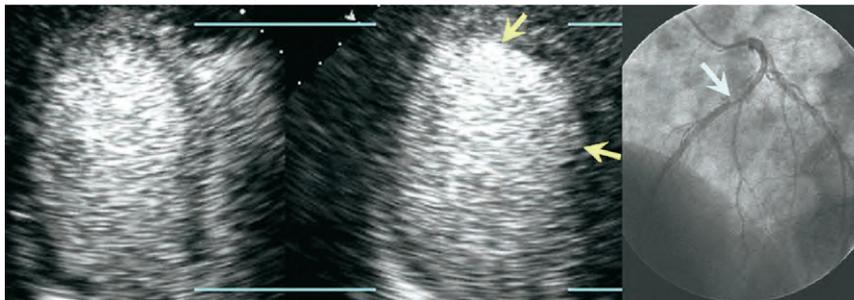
Exercise stress echocardiogram with contrast and subsequent coronary angiogram in a patient with exertional chest pain. (Left panel and corresponding Movie File 7) Exercise stress echocardiogram with contrast enhancement, apical long-axis views at end-systole. Left view is taken at rest; right view taken after stress. View shows LV cavity dilation and apical deformity (between yellow arrows) due to regional wall-motion abnormality in the mid to apical anteroseptal region on the poststress image. The lower yellow arrow shows hinge point in midanteroseptum. Findings are consistent with ischemia in the left anterior descending (LAD) coronary artery territory. (Right panel and corresponding Movie File 8) Coronary angiogram (left anterior oblique view) in same patient. Image shows high-grade mid-LAD artery stenosis (white arrow).  View video clips online.
